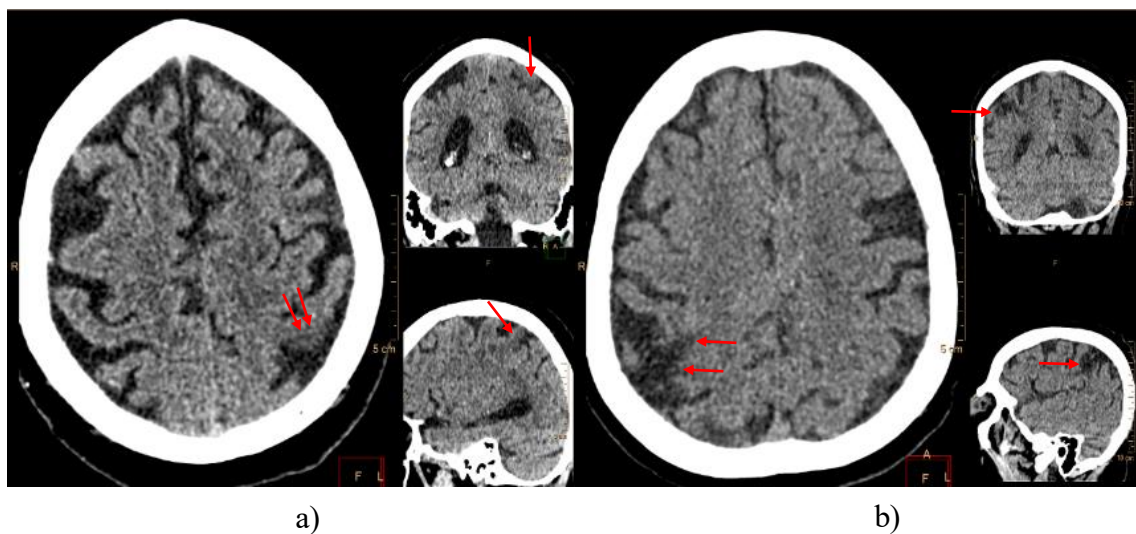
Multiplanar reformats of unenhanced brain CTs. a) Very subtle left postcentral hypodensity with loss of the grey-white matter differentiation, corresponding to a recent left middle cerebral artery (MCA) infarct (arrows). b) Marked hypodensity in the right postcentral region, contributable to a chronic right MCA infarct (arrows). Both cases were regarded as positive in the brain CT assessment.
